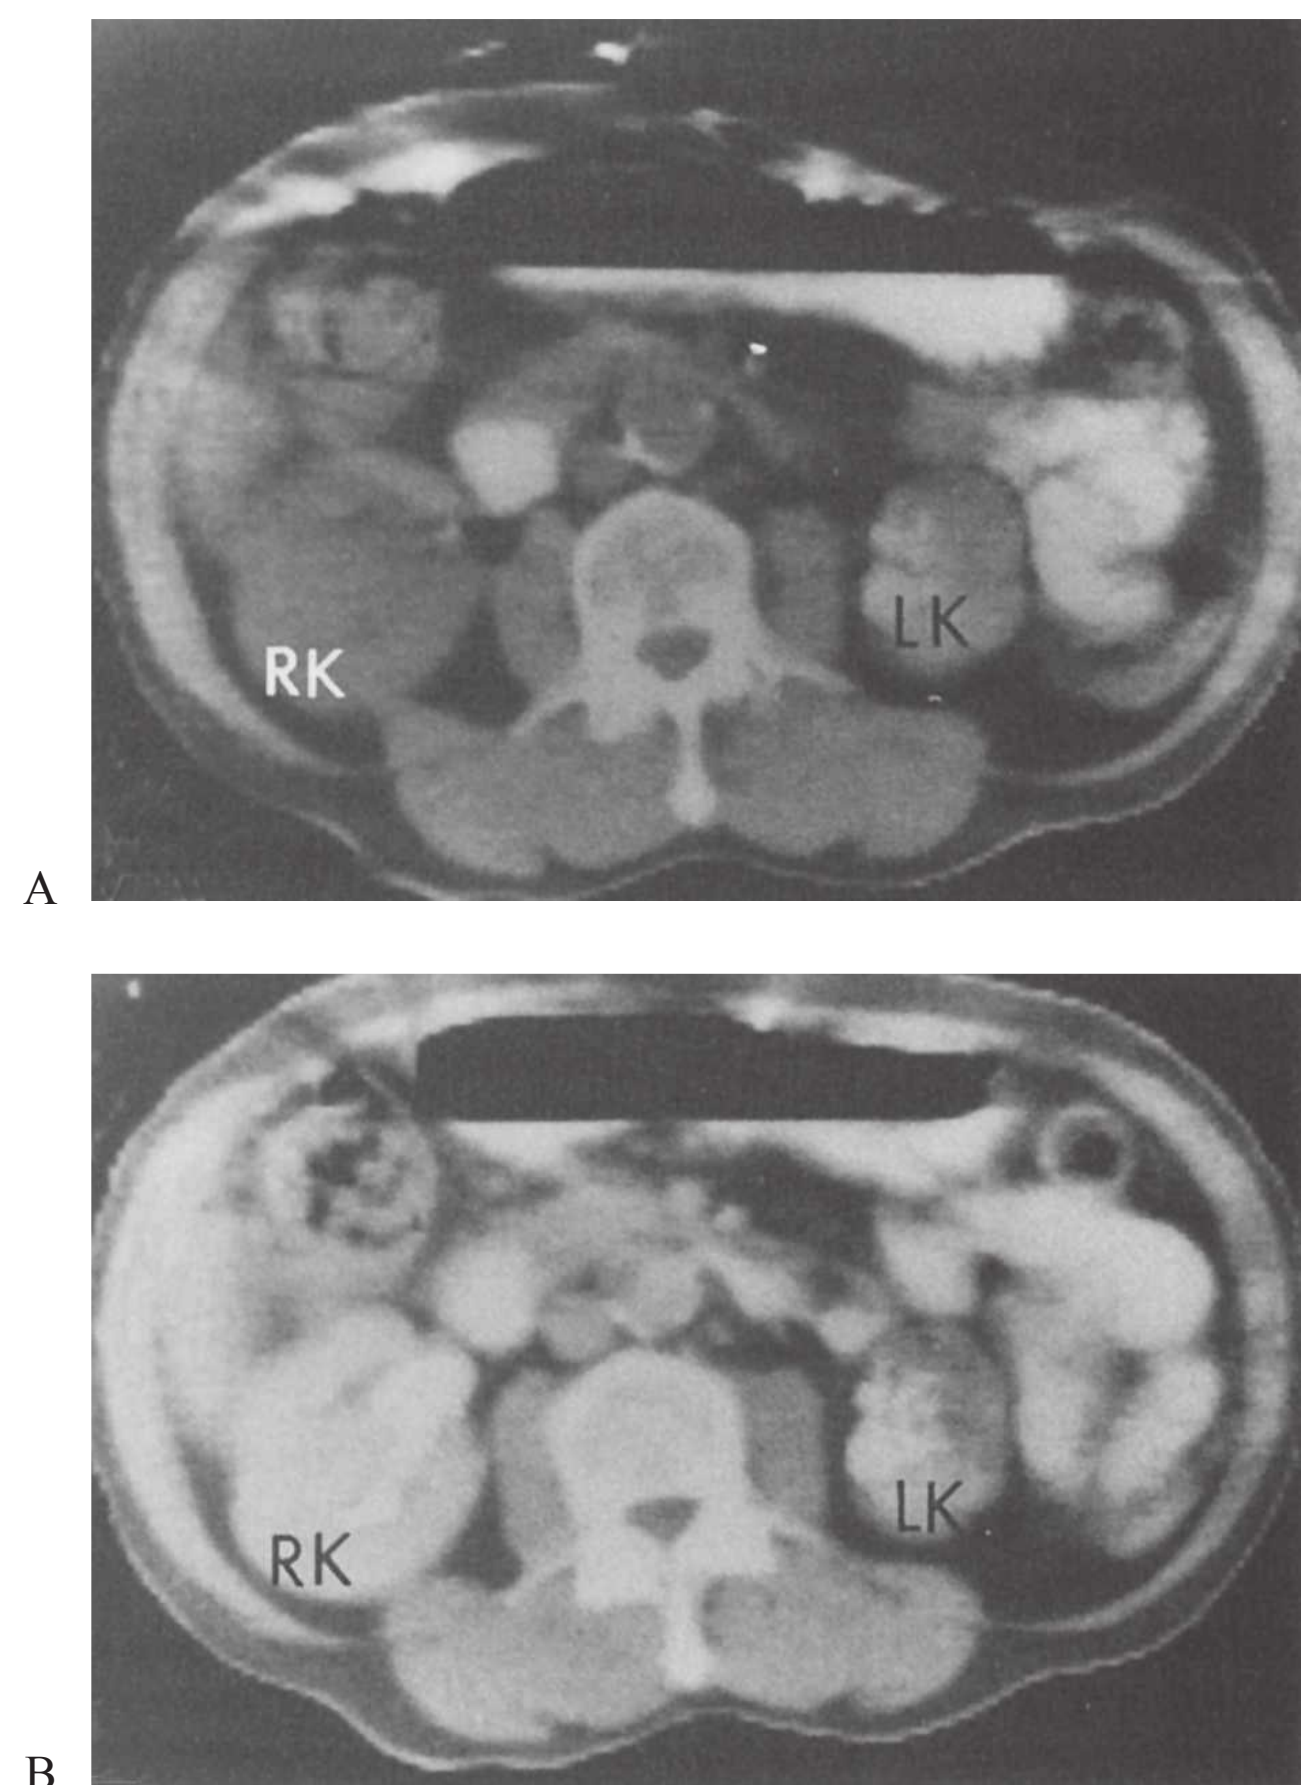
Computed tomography scans (A) before and (B) after the intravenous administration of contrast. There is a calcified nonfunctioning left kidney characteristic of a tuberculous autonephrectomy in a patient with old pulmonary tuberculosis. The right kidney is normal. LK, left kidney; RK, right kidney.
